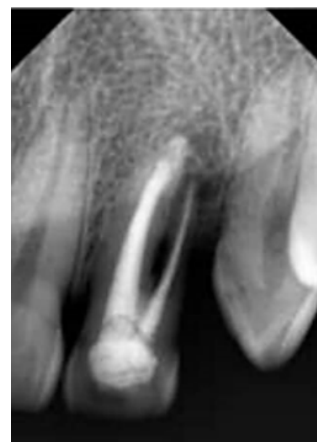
Post endodontic radiograph of #22
